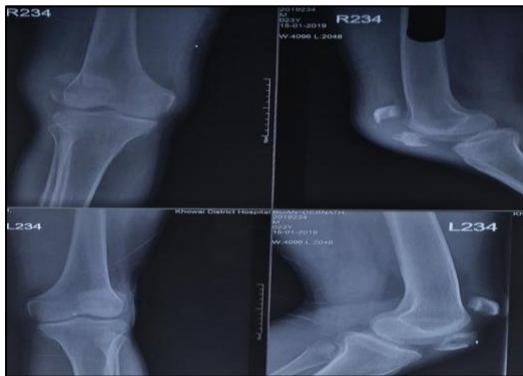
X-rays of both knees at presentation.
